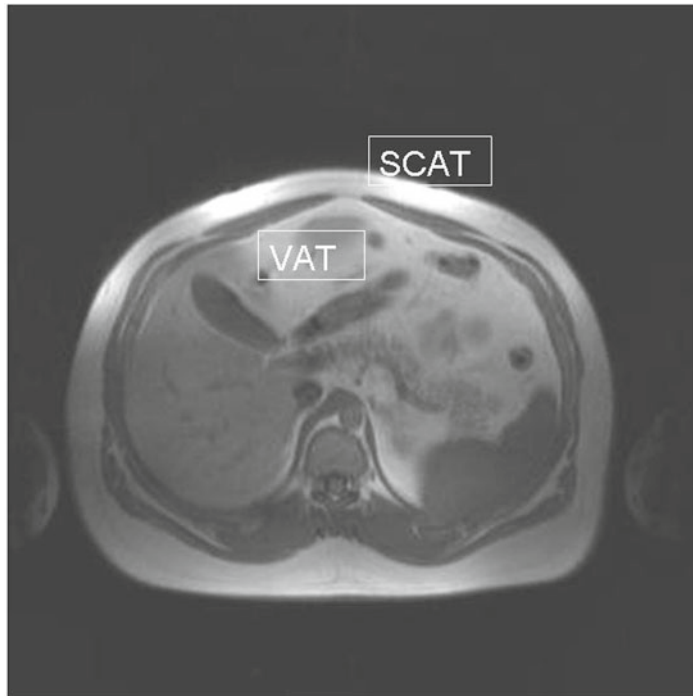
Abdominal fat distribution evaluated by MRI. Transverse T1-weighted MRI image of the abdomen at L3 level, with subdivision of abdominal adipose tissue into subcutaneous adipose tissue (*SCAT*) and visceral adipose tissue (*VAT*)
